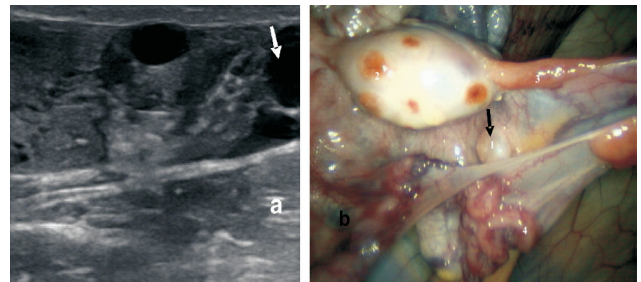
Parovarian cyst in adnexa (arrow). (a) Ultrasound image (b) Laparoscopic image.
